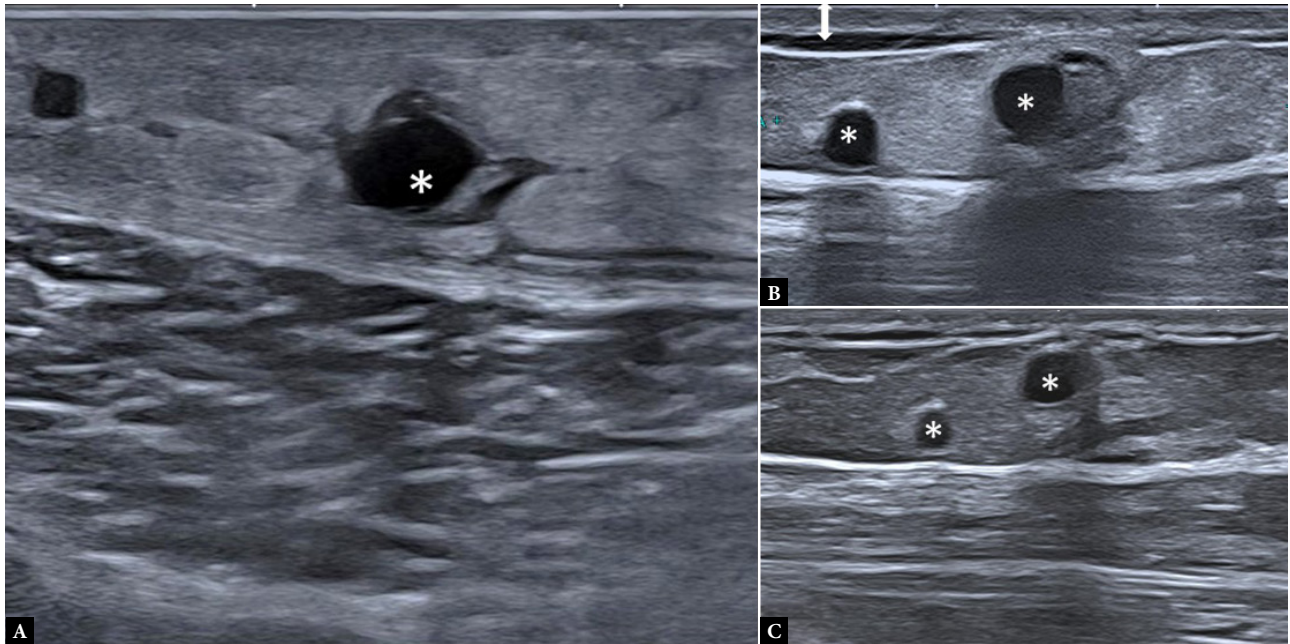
Blunt trauma panniculitis. Evolution after acute blunt trauma at the lateral aspect of the arm: A. Two days after trauma: predominantly lobular panniculitis sonographic pattern and round cysts (*); B. Four weeks later: decrease in the hyperechoic area and normalization of superficial hypodermal and dermal echogenicity; C. Three months after trauma: subtle hyperechogenicity around persistent cysts
